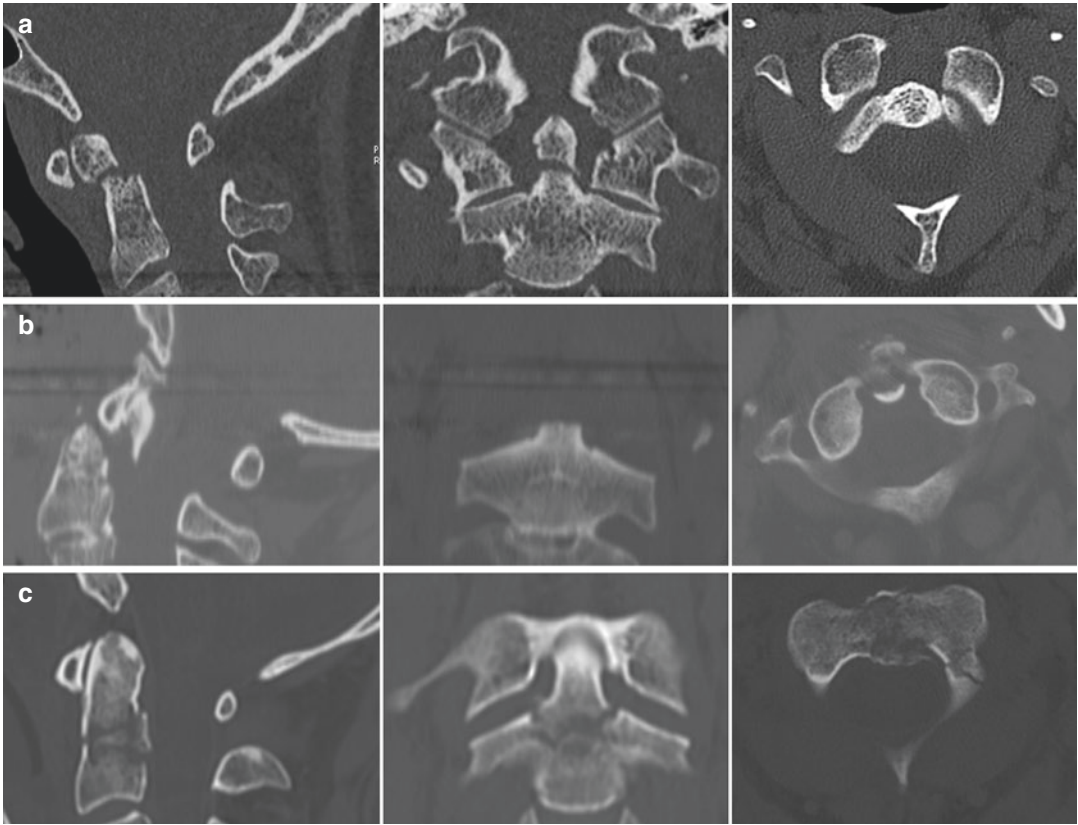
Fractures of the odontoid process: 2D-reformatted sagittal and coronal, and source axial CT images of flexion (a) and extension (b) “high,” and “low” (c) fractures
